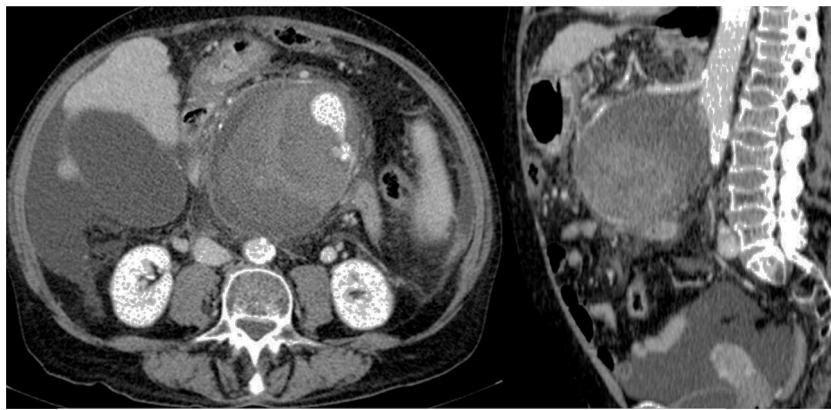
Abdominal CTA: showing the PSMA (102 × 98 × 103 mm [AP × LL × CC]).
